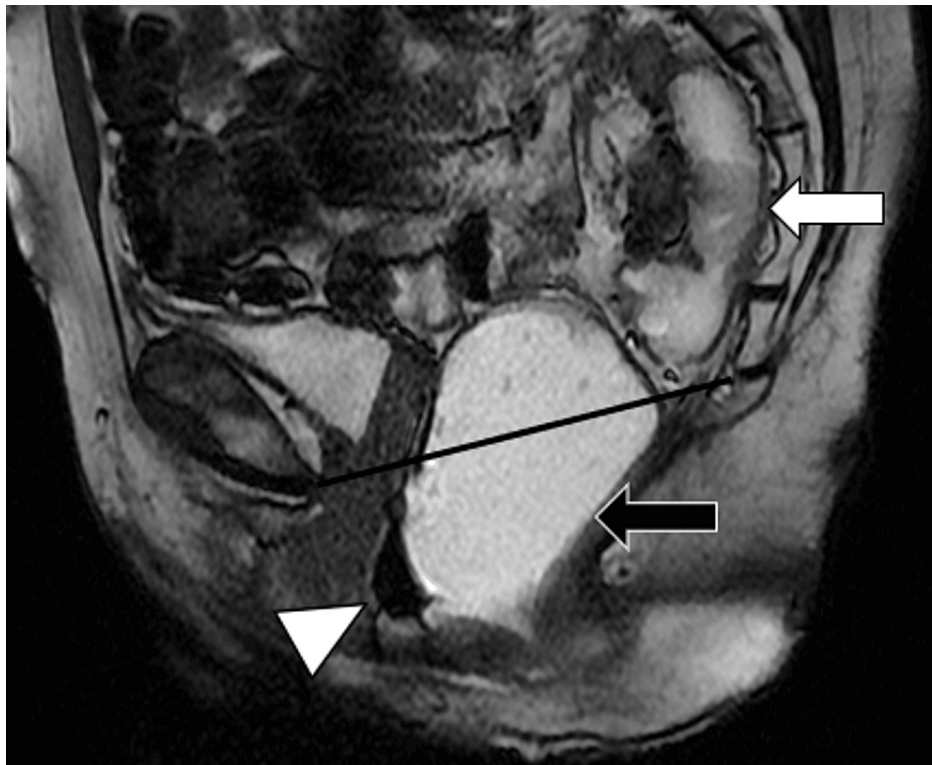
Sagittal T2-weighted image of the pelvis showing persistent retrorectal herniation of the sigmoid colon (white arrow) and pelvic floor laxity during the evacuation phase of MR defecography. The distended rectum (black arrow) descends below the pubococcygeal line (black line). An anterior wall rectocele is seen (white arrowhead).
